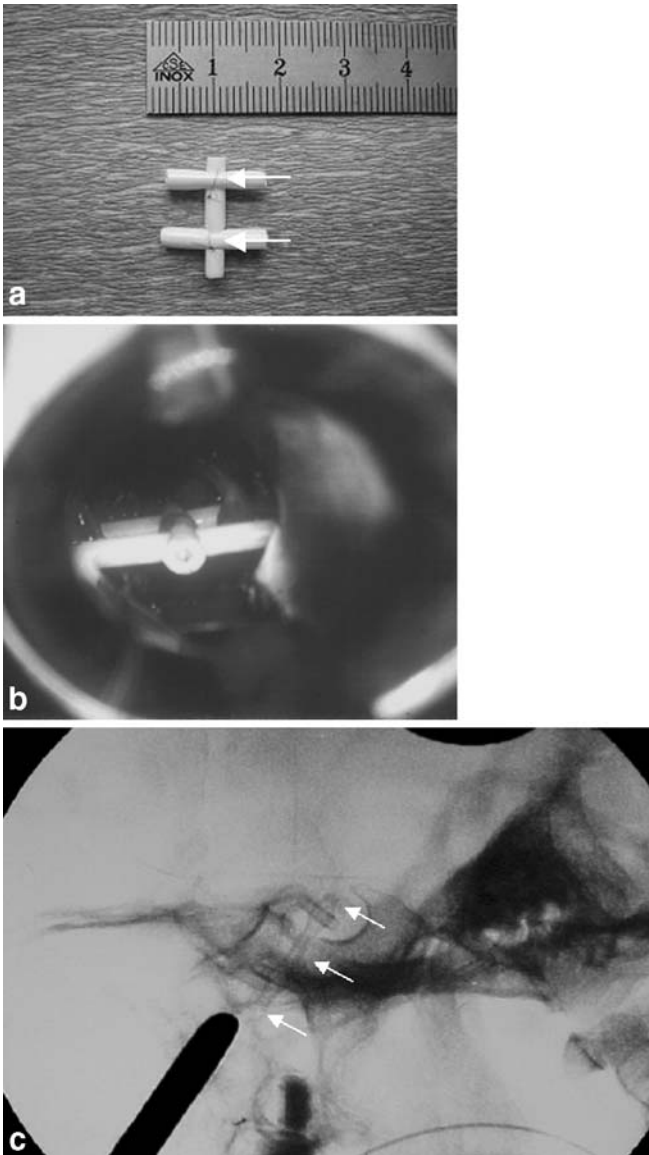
a Custom-made shunt after Spaziante and de Divitis [9] with a simple piece of silastic tube; *arrows* point at 60 prolene suture to secure the parts of the H-shaped shunt. b Per-operative view of the cysto-sphenoidal shunt. The *upper horizontal tube* allows the shunt not to escape from the drained intrasellar portion of the craniopharyngioma cyst and the *lower horizontal tube* is seen in the sphenoidal sinus. c Lateral X-ray view of the skull (*arrows* delineate the shunt)
